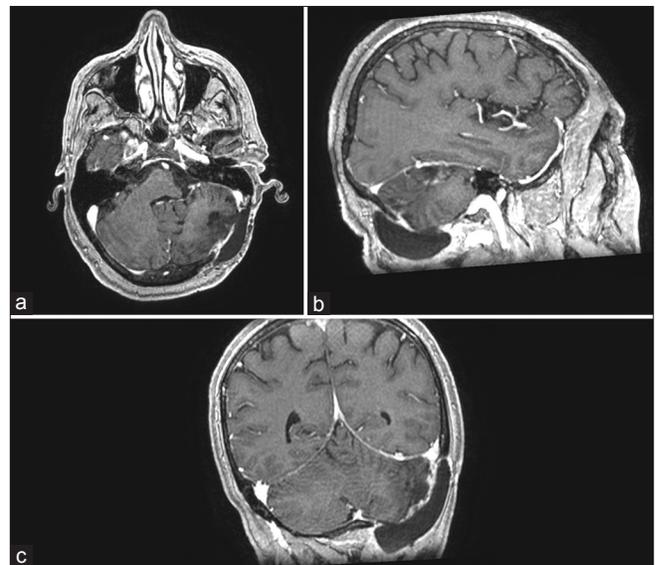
Postoperative axial (a), sagittal (b), and coronal (c) T1-weighted magnetic resonance imaging with gadolinium images documented a gross total resection of the lesion.
